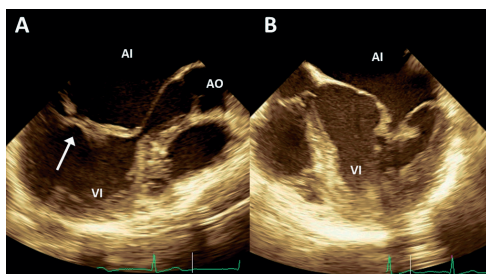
Transesophageal echocardiography. A. Mid-esophageal view at 120° in diastole: anterior and posterior leaflets connected by a fibrous tissue bridge (arrow). B. Mid-esophageal view at 20° in systole: thickened and shortened tensor apparatus that prevents mitral leaflets from proper coaptation. Ao: Aorta. LA: Left atrium. LV: Left ventricle.
